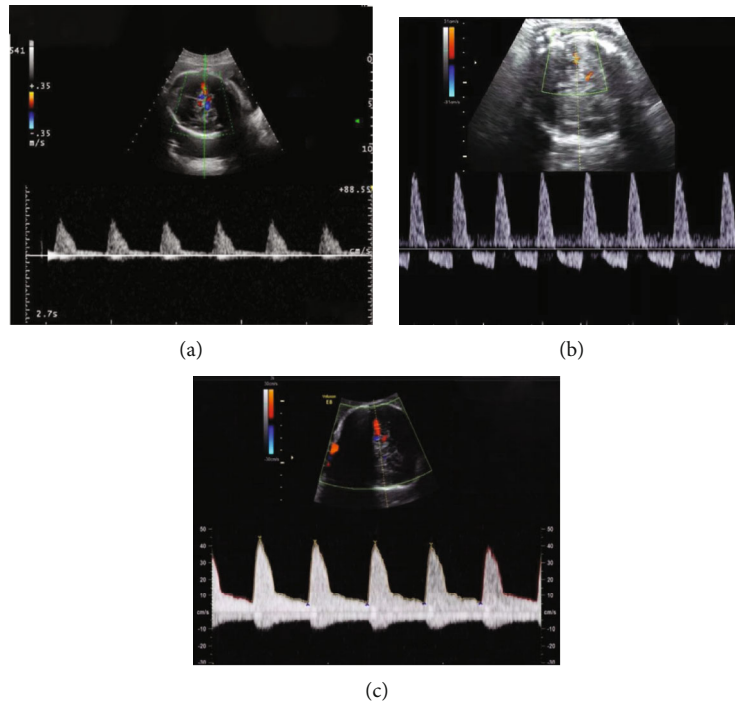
Blood flow spectra of fetal MCA. (a) Doppler waveform of MCA blood flow in pregnant women under transabdominal ultrasound in the normal group. (b) Doppler waveform of abnormal MCA blood flow in the mild group. (c) Doppler waveform of MCA blood flow abnormality in the severe group.
